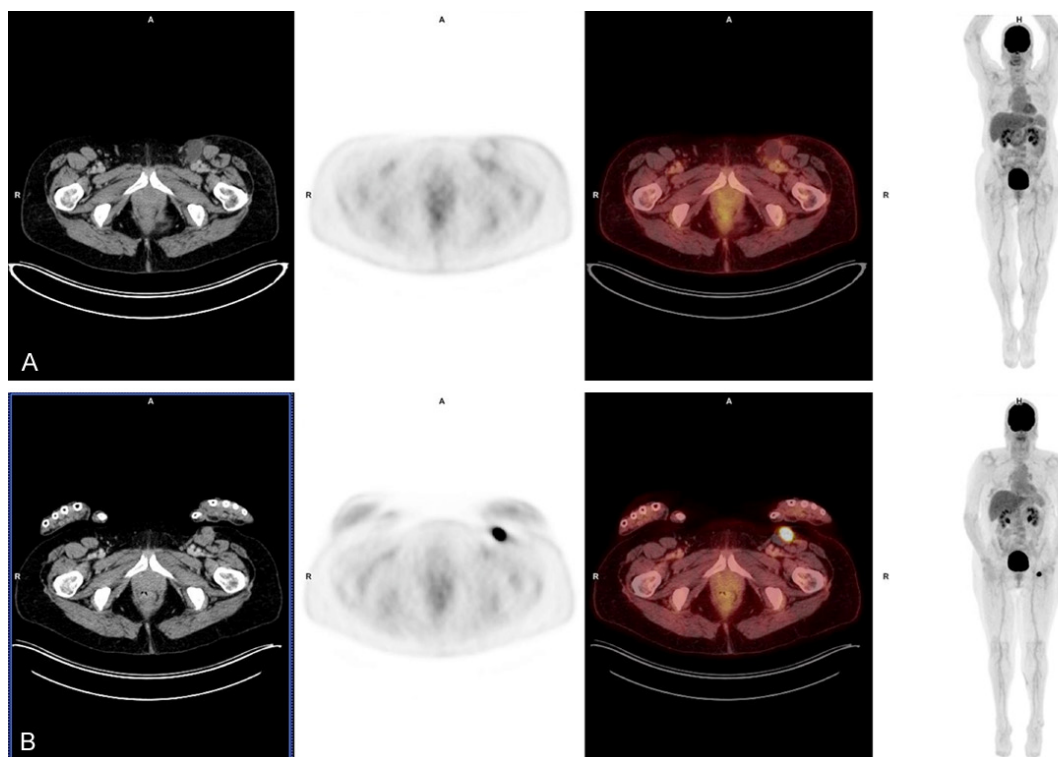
Characterization of PET/CT in a 69-year old patient. A: The initial PET/CT after a superficial lymph node dissection showed no signs of regional- or distant metastasis. B: In further detail, in a PET/CT after 7 months a solitary FDG-avid pathological inguinal lymph node on the left side was observed. This lymph node was resected and showed regional metastasis without extra nodal growth. No distant metastasis was seen.
